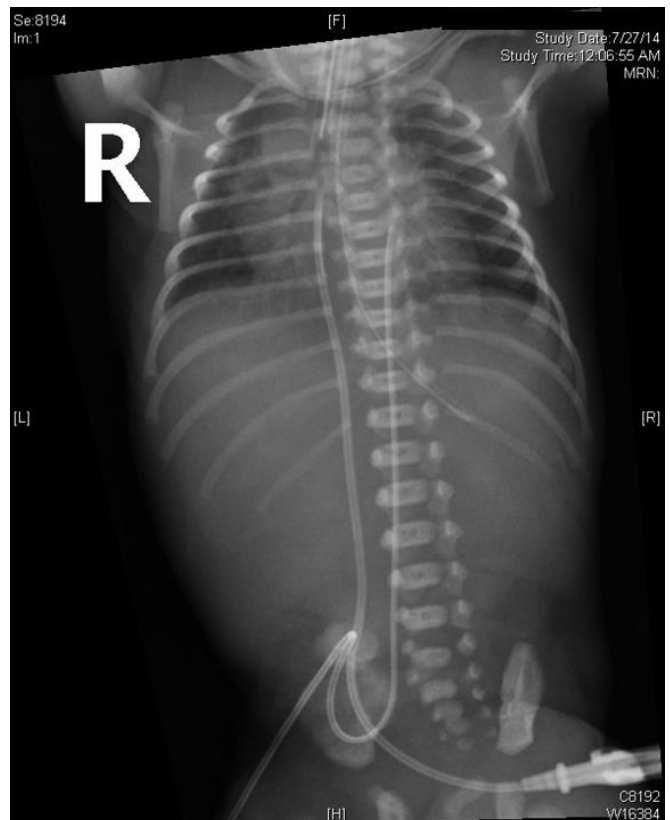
X-Ray AP view after giving surfactant showing clear lung fields.
